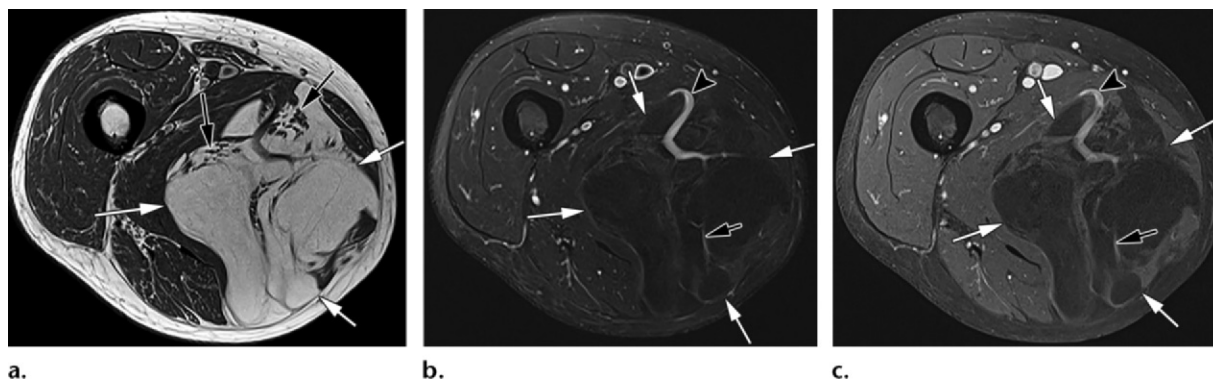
ALT in an 82-year-old man with a painful right medial thigh mass. (a) Axial T1-weighted image shows a large, fat-containing, predominantly intramuscular mass (white arrows) with muscle bundles (black arrows) traversing through the mass and thickened internal septa. (b) Axial T2-weighted fat-saturated image shows the mass (white arrows) with suppression of fat signal intensity, mildly hyperintense internal septa (black arrow), and an enlarged vessel (black arrowhead). (c) Axial postcontrast fat-saturated T1-weighted image of the mass (white arrows) shows suppressed fat signal intensity, thick enhancing internal septa (black arrow), and an enlarged vessel (black arrowhead).
